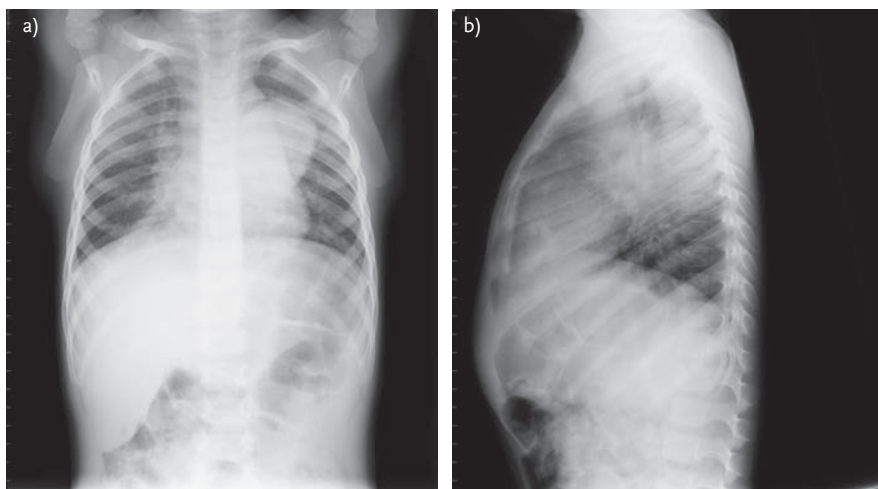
Hodgkin lymphoma in 7-year-old boy. a) Anteroposterior and b) lateral chest radiographs demonstrate a large anterior mediastinal mass lesion.
